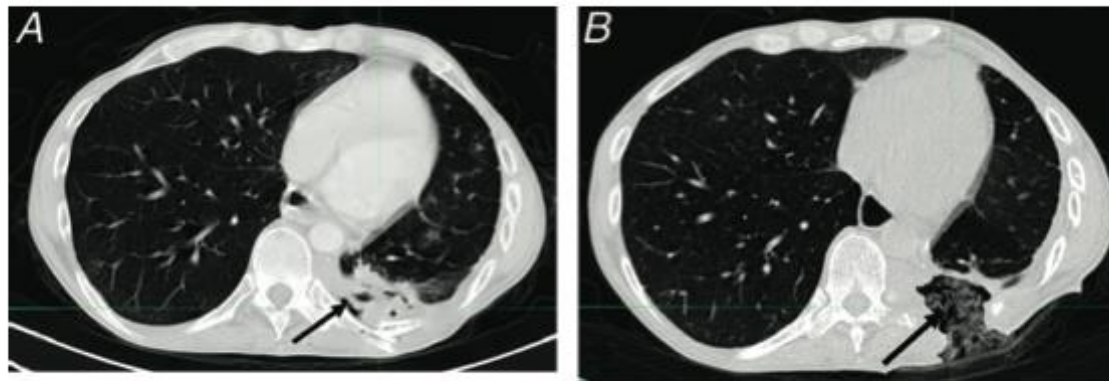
A, Representative axial computed tomography (CT) chest image without contrast at 17 months post-stereotactic body radiation therapy (SBRT). Arrow indicates air in lesion suggesting abscess. B, Representative axial CT chest image without contrast at 19 months post-SBRT. Arrow indicates abscess cavity after resection and marsupialization.
